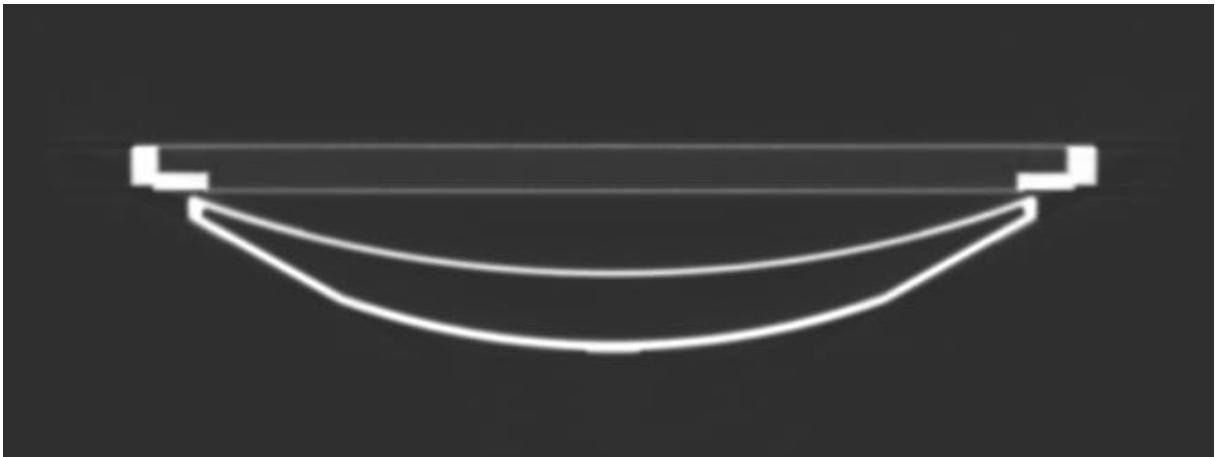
The couch of the Toshiba Aquilion LB wide bore CT Scanner on the CT image
